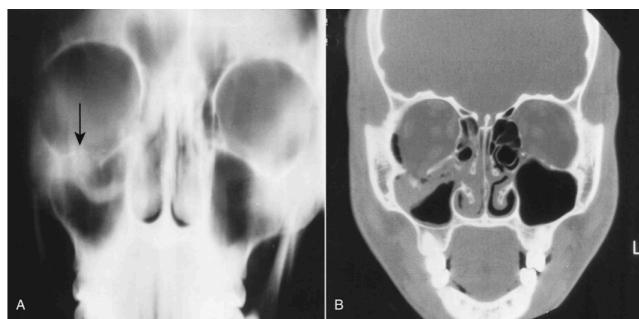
A, The tomographic view demonstrates a disruption of orbital floor (arrow). B, Computed tomography scan showing disruptions of the medial wall and floor of the right orbit.(Hupp 496)⁹
